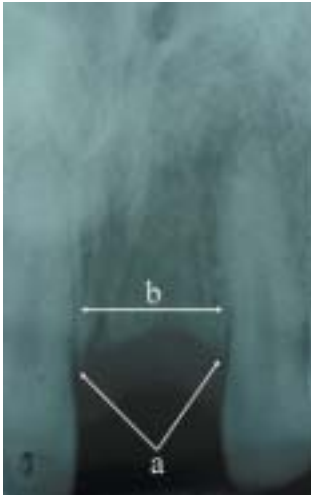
Pre-operative planning: radiographic assessment
